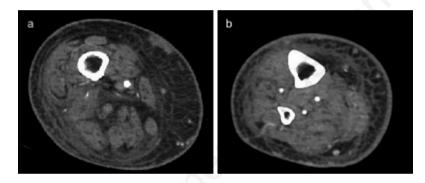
Axial computed tomography imaging of the right leg demonstrating diffuse subcutaneous stranding and edema: a) at the level of the thigh; b) at the level of the calf.
